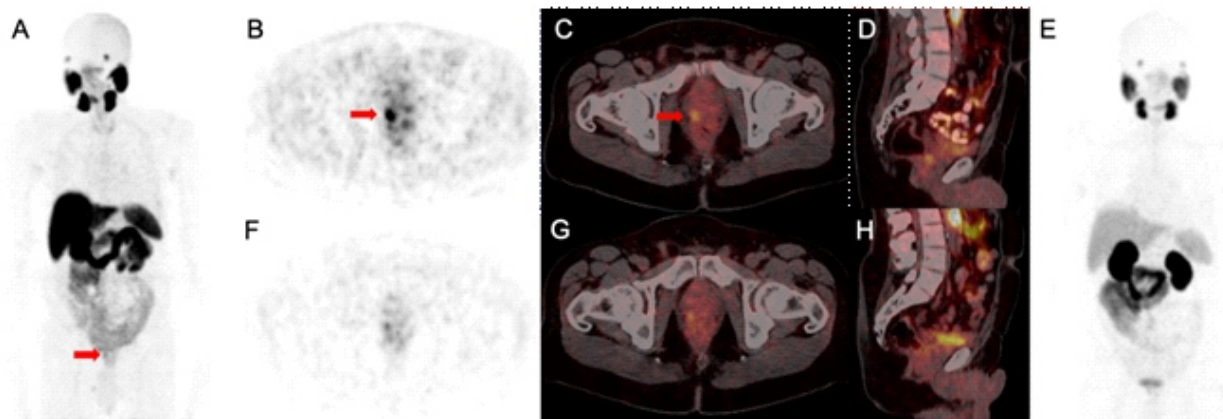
68 year old male, Gleason grade 2, with PSA 2.04ng/ml. ^{18}F -1007-PSMA PET mip (A), axial PET (B) and fused axial (B) and fused sagittal (D) images demonstrating para-rectal recurrence (arrow). ^{68}Ga -PSMA-11 PET mip (E), axial PET (F), fused axial (G) and fused sagittal (H) images demonstrating negative uptake.
